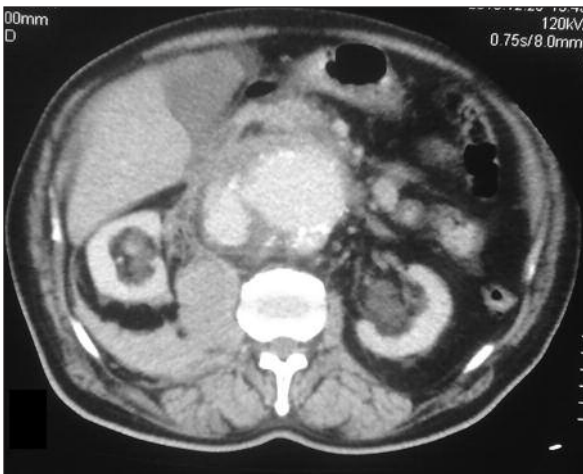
Abdominal CT showing the abdominal aortic aneurysm and retroperitoneal hematoma.
